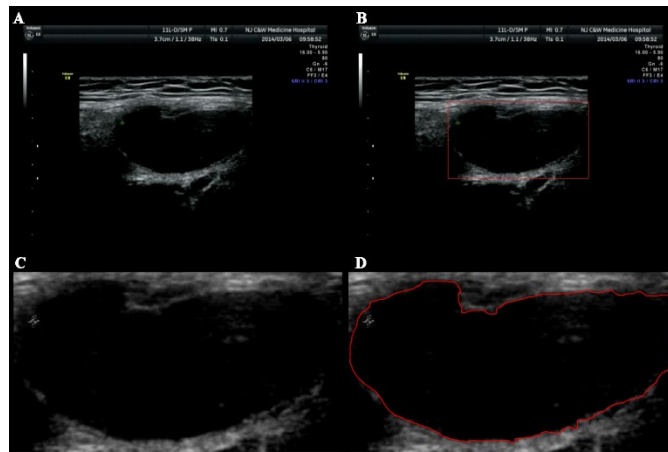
(A) HV-CD ultrasound original image; (B) HV-CD mass ROI; (C-D) HV-CD segmentation and edge-labeled results
